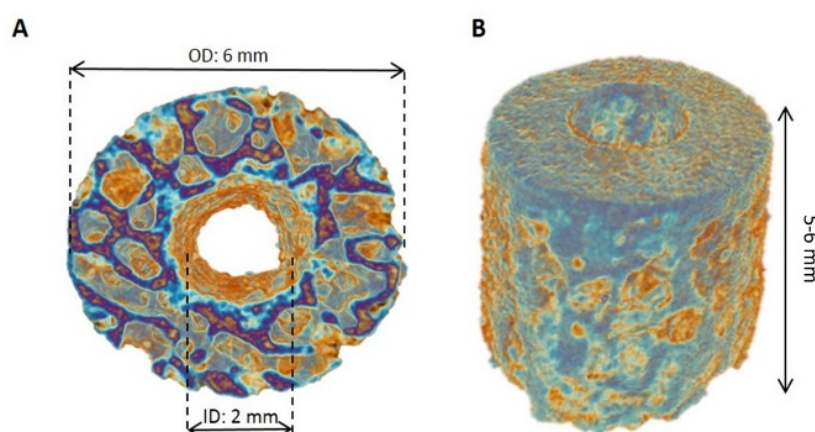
3D image from a μ CT scan of an engineered human bone cylinder injury model. (A) Top and (B) lateral view. Human bone grafts were extracted following a two-step drilling protocol. A 2mm diameter trephine was used to drill the surface of the femoral head. Then, a hollow saw (6 mm) with a pilot drill (2 mm) attached was used to drill the outer diameter of the graft. The length of the bone graft varied between 5-6 mm. Purple colour indicates low density tissue, orange colour indicates high density tissue. Inner diameter (ID), outer diameter (OD).
